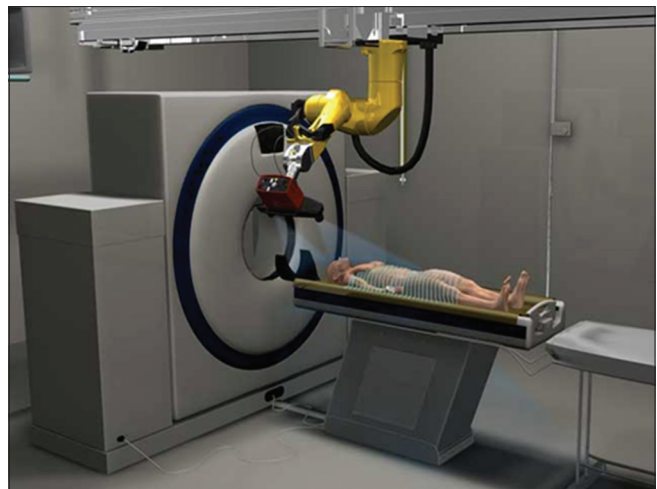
A representative image of the VIRTOBOT system showing computed tomography couch analyzer with scanners (Image courtesy: Int J Med Robot 2010; 6 (1): 18-27)
